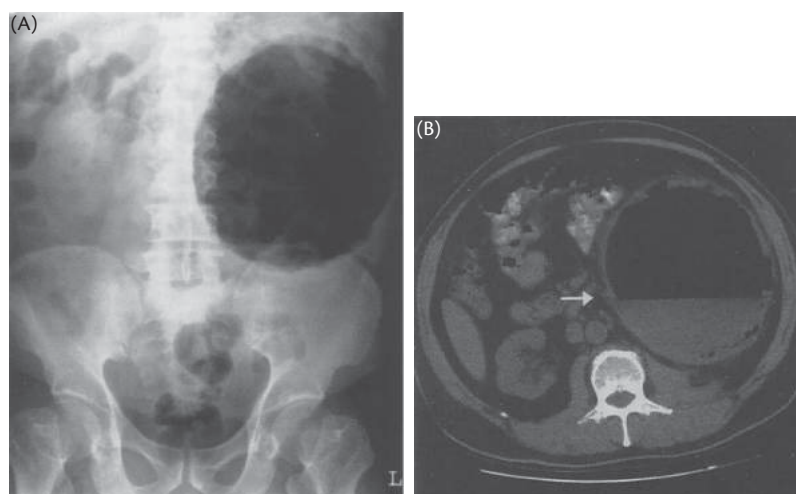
Abdominal X ray and CT scan of emphysematous pyelonephritis.
